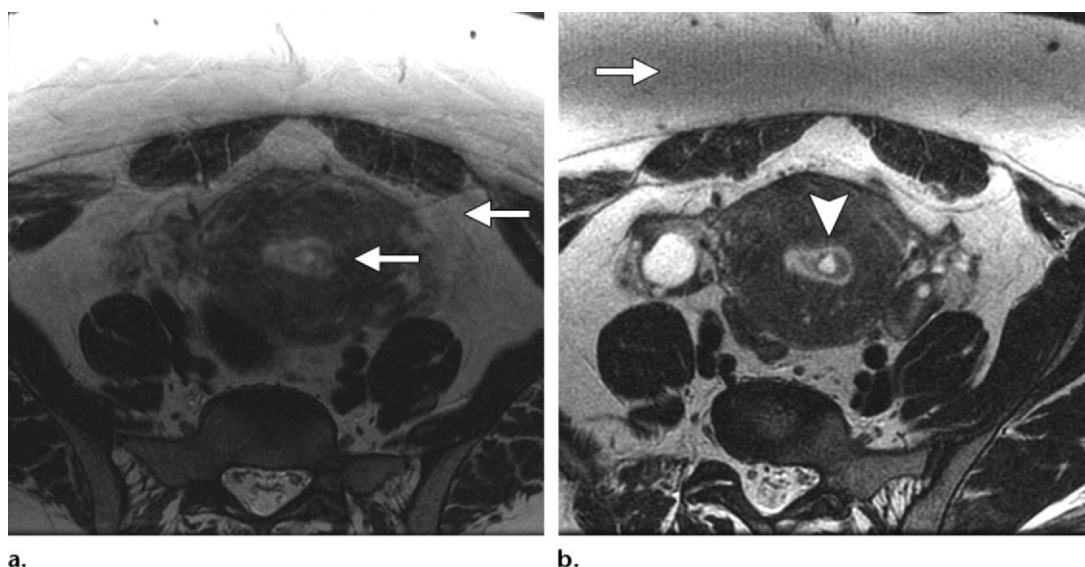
Use of an anterior saturation band and adjusting matrix size to eliminate artifacts and improve SNR. (a) Axial oblique high-resolution T2-weighted MR image obtained at the level of the uterus with a 320×256 matrix shows motion artifacts (arrows) and poor SNR, which limit evaluation of the endometrial-myometrial interface. (b) Axial oblique high-resolution T2-weighted MR image obtained at the level of the uterus with a 256×256 matrix shows a polypoid mass (arrowhead) that is confined to the endometrial cavity. Placement of an anterior saturation band (arrow) eliminates motion artifacts from anterior abdominal wall fat, and the use of a smaller matrix increases SNR and improves image quality.
